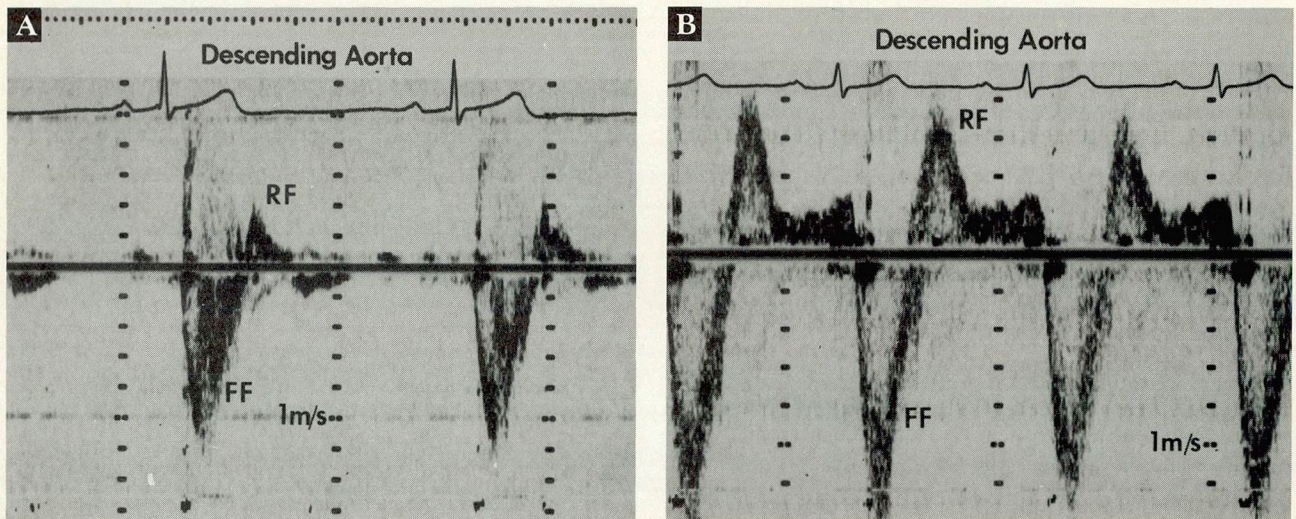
Pulsed-wave Doppler recordings. In A, the proximal descending aorta in a patient with mild aortic regurgitation; note the small and early diastolic retrograde flow (RF) relative to forward flow (FF). In B, the proximal descending aorta in a patient with severe aortic regurgitation; retrograde flow is increased and holodiastolic.
